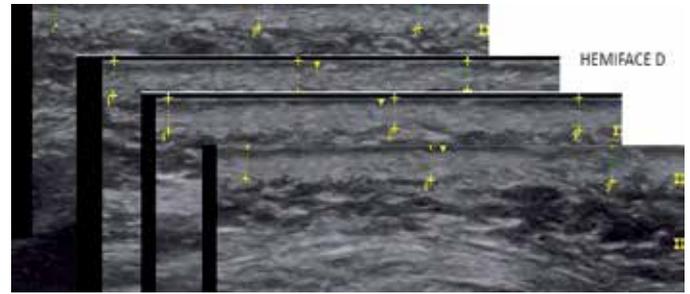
Ultrasound images of the malar region captured at the different experimental occasions D0 (first visit), D30 (30-days visit), D60 (60-days visit), and D90 (90-days visit). The dermal area is delimited between the yellow markings, in the upper portion of each image
